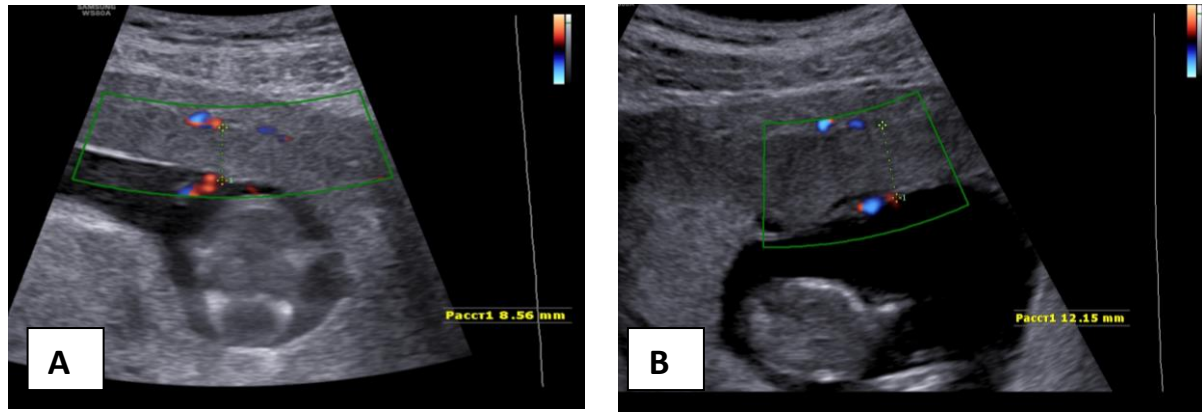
Ultrasound. A - thinning of the placenta and reducing its volume in women with adenomyosis with the traditional method of pregnancy at 12 weeks of gestation; B is the normal thickness and volume of the placenta in a woman with adenomyosis who has a 12-week gestation schedule.
